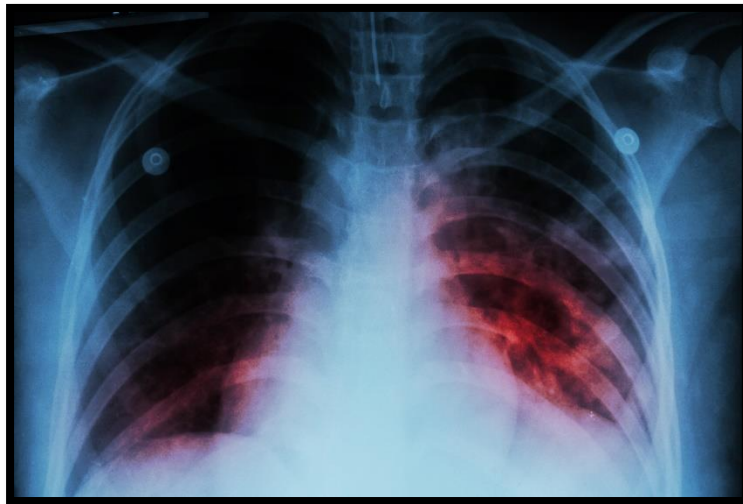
Tuberculosis X-Ray [5]
